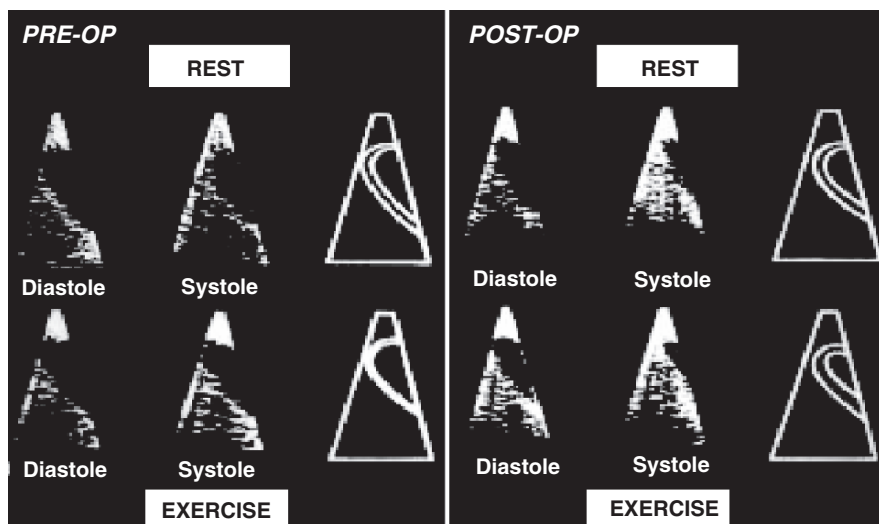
Stress echocardiography in its infancy: not easy on the eyes. Exercise echocardiograms are shown before (*left panel*) and after (*right panel*) coronary artery bypass surgery. At that time (1979), image quality was so poor that even obtaining a single “typical example” for publication purposes was a challenge. (From [16])
